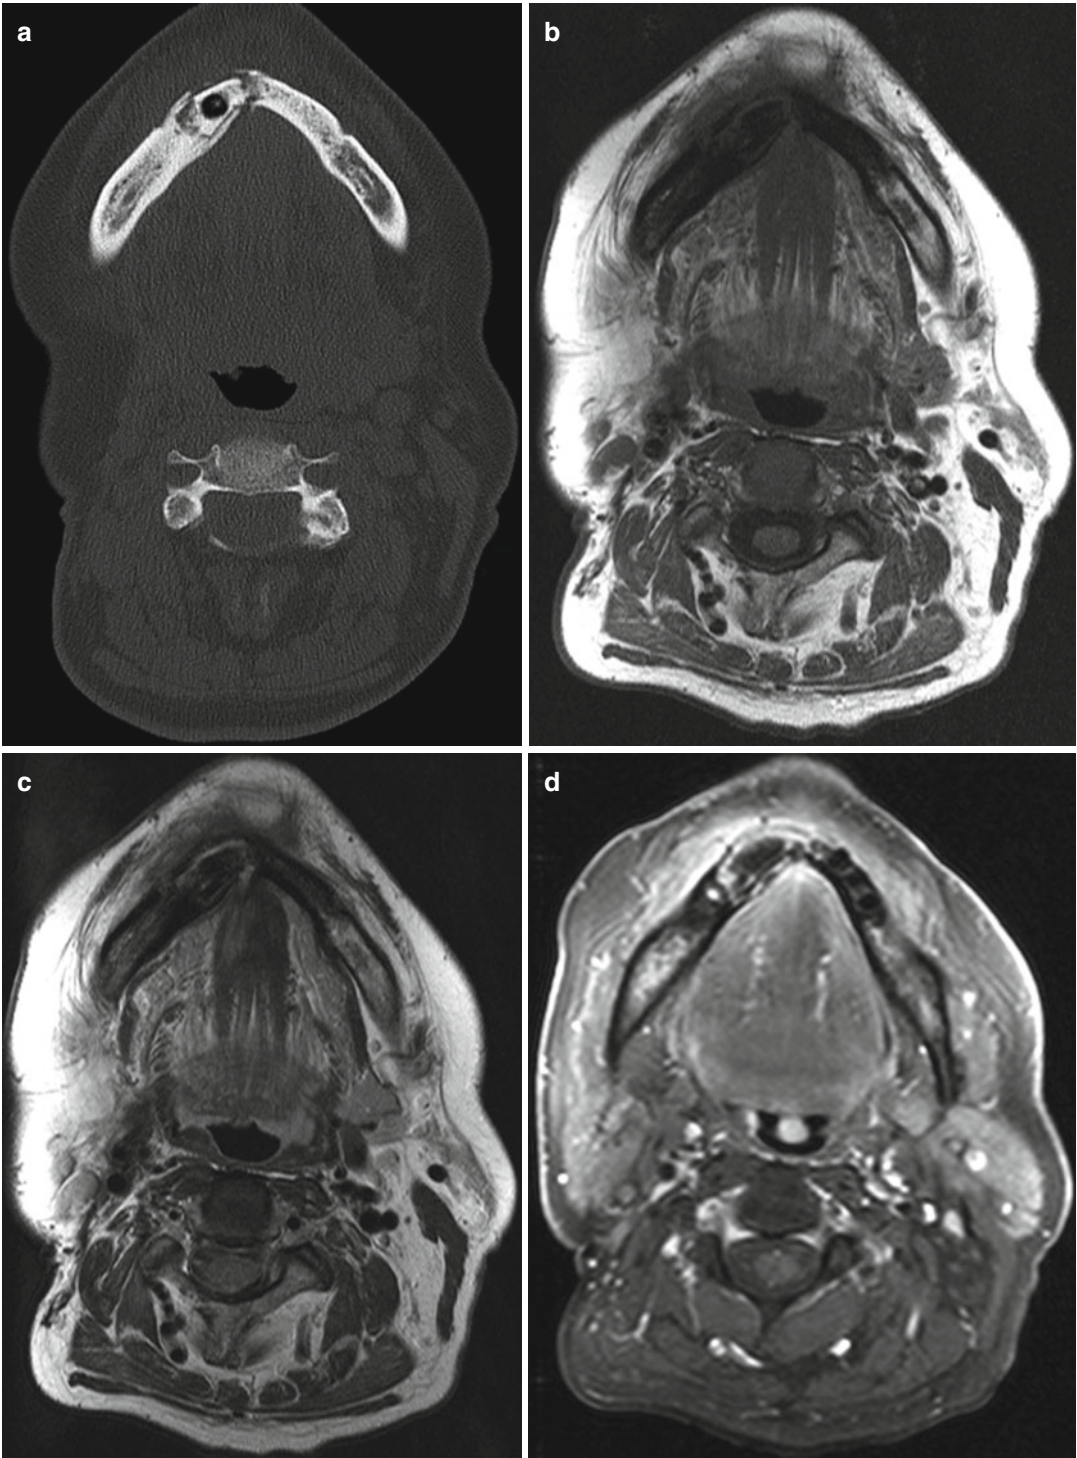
(a–d) A 60-year-old male with prostate cancer. Axial CT image (a) shows bony sequestrum in the right mandibular body as well as medullar and cortical sclerosis on both sides. The corresponding unenhanced T1-weighted image (b) demonstrates the sclerotic lesions as areas with low signal
